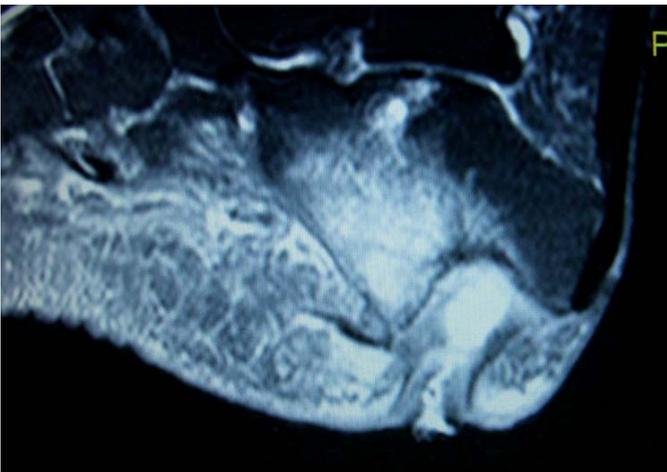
(Patient #2) Pre-operative MRI. Note the large sinus tract and sequestrum in the calcaneal tuberosity.
